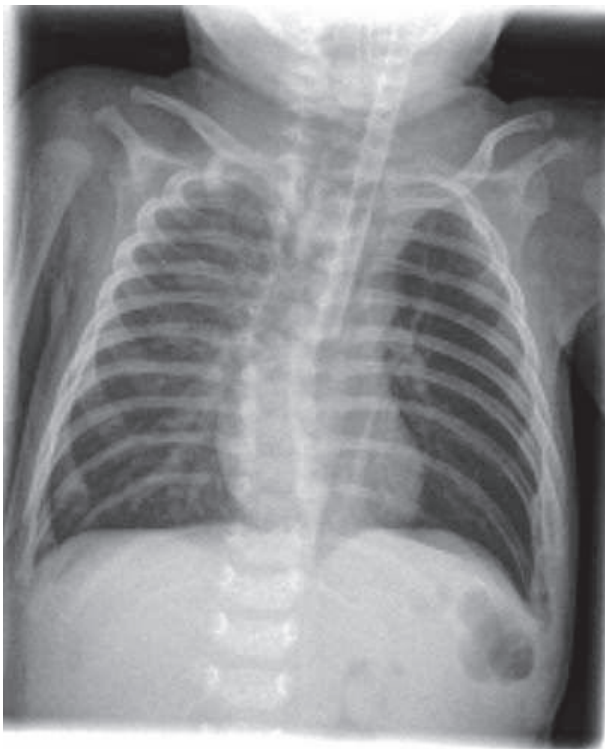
Plain chest X-ray showing tracheo-esophageally settled CPAP tube.
